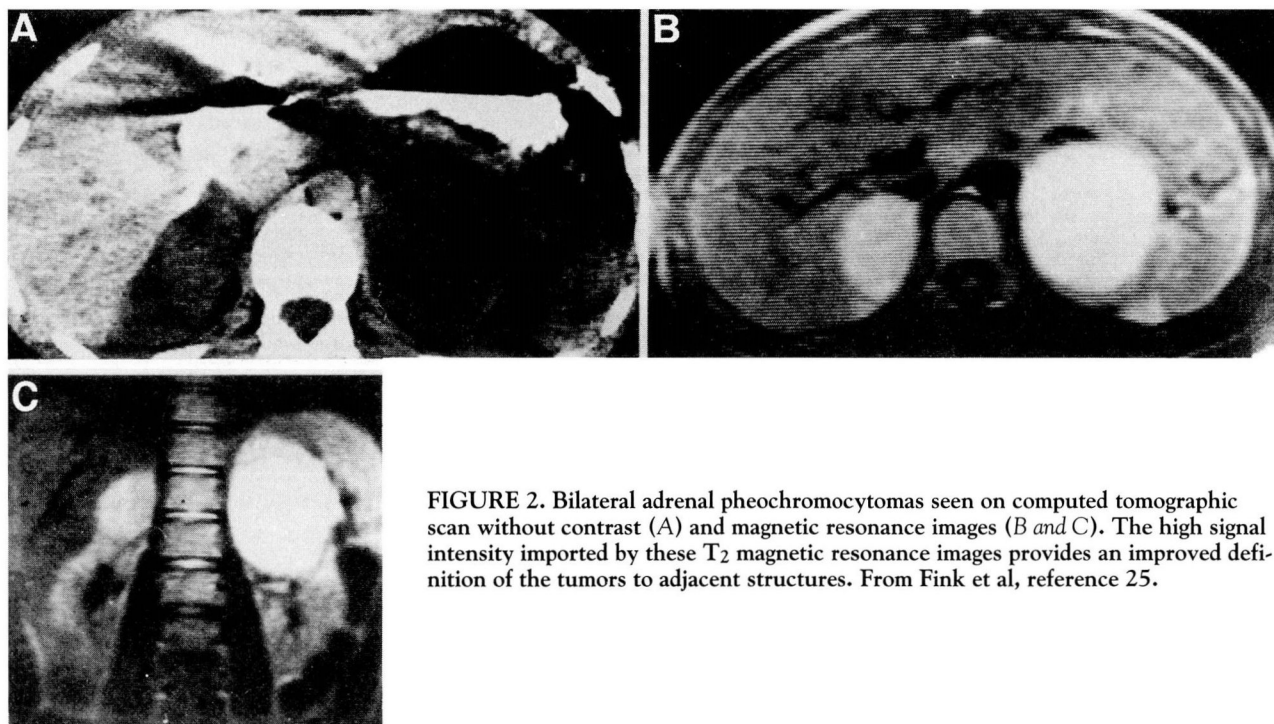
Bilateral adrenal pheochromocytomas seen on computed tomographic scan without contrast (A) and magnetic resonance images (B and C). The high signal intensity imparted by these T₂ magnetic resonance images provides an improved definition of the tumors to adjacent structures. From Fink et al, reference 25.
